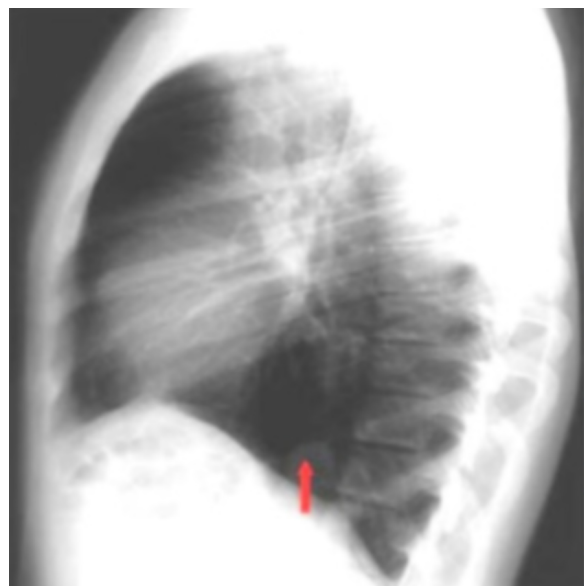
45-year-old man with Bochdalek hernia. Lateral chest radiograph shows a small round opacity (red arrow) in contact with the posterior portion of the right hemidiaphragm.
